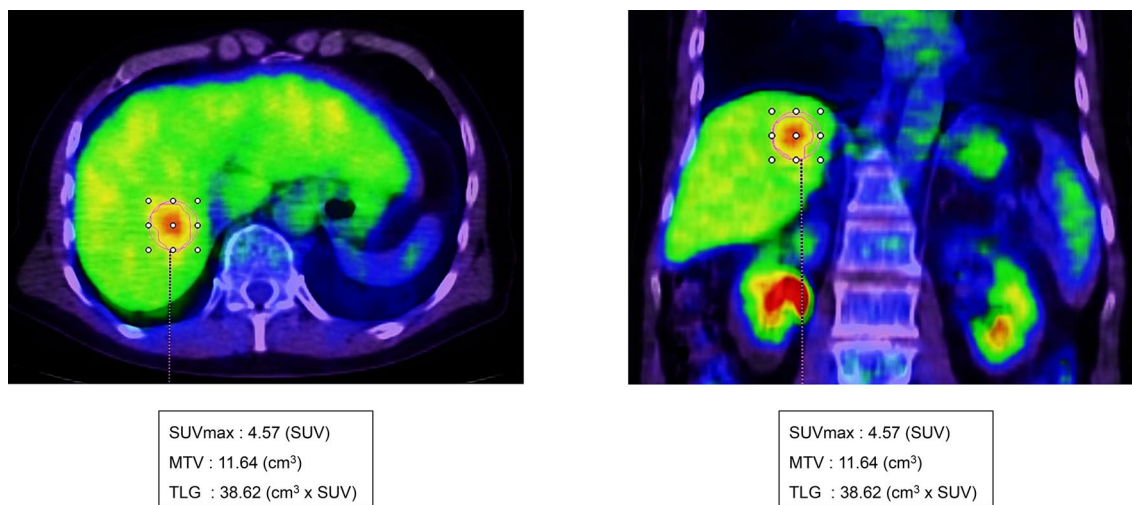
The representative figure of tumor SUVmax, MTV, and TLG
